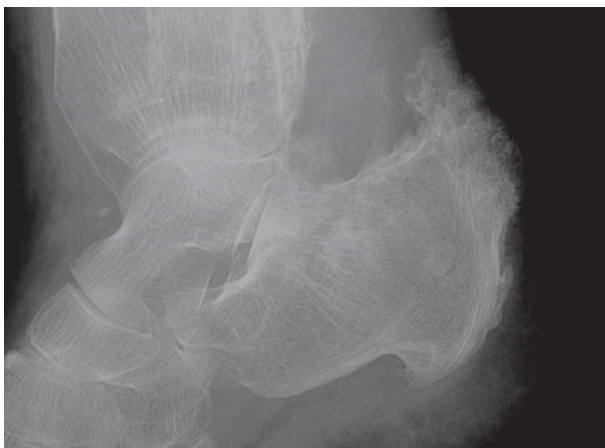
X-ray of the right calcaneus: rough periosteal bone deposits along the edge of the calcaneus
